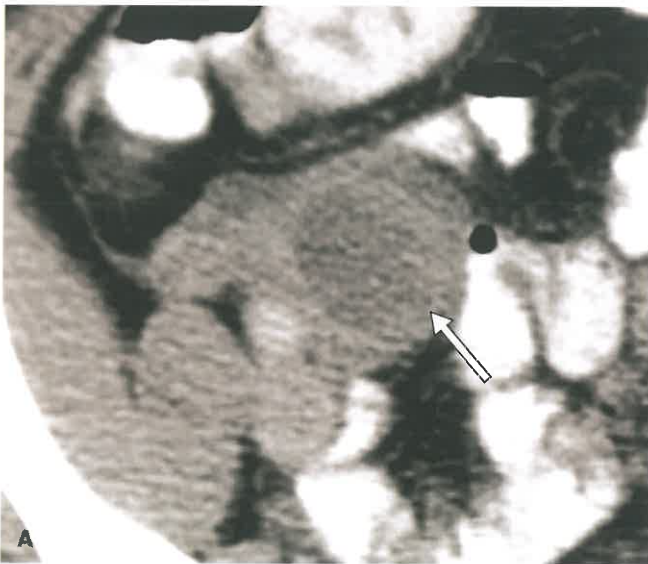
Physiologic Ovarian Cysts. A: Postcontrast CT reveals a thin-walled 2.6-cm cyst (arrow) arising from the right ovary in a 28-year-old woman. The appearance and size of this ovarian cyst are consistent with being a dominant follicle. This is a physiologic cyst and no follow-up is needed. B: Postcontrast CT in a 26-year-old woman shows an 18-mm right ovarian cyst (arrow) with intense rim enhancement. This appearance is consistent with a normal benign corpus luteum. A diagnosis of mittelschmerz was made after appendicitis was ruled out on this CT. C: Another CT performed for right lower quadrant pain in a 34 year old revealed a 3-cm right ovarian cyst with a fluid–fluid layer (arrow) yielding a diagnosis of hemorrhagic ovarian cyst as a cause for her pain. The dependent high attenuation fluid represents blood. Follow-up pelvic US in 10 weeks confirmed complete resolution.
